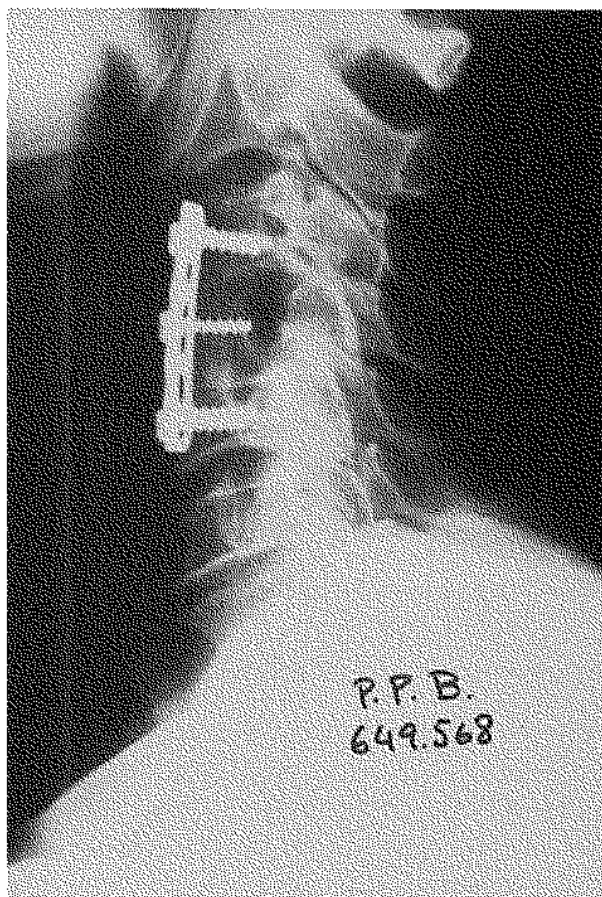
Lateral radiograph after anterior decompression and fusion.
